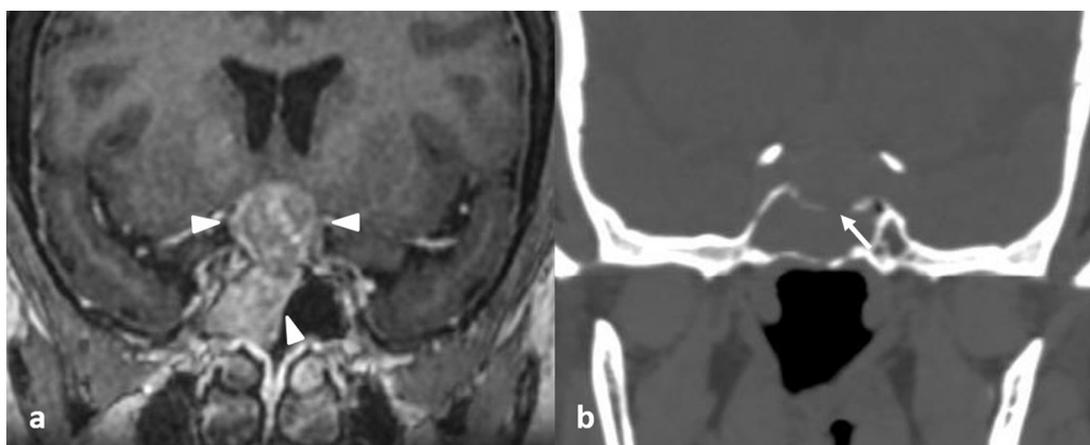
Thirty-five-year-old woman with head ache and bitemporal homonymous hemianopia: a: post-contrast T1-weighted MR image shows well enhancing sellar – suprasellar lesion with extension into sphenoid sinus consistent with pituitary macroadenoma (arrowheads); b: coronal CT image in bone window shows erosion of sellar floor with extension of lesion into sphenoid sinus (arrow).
